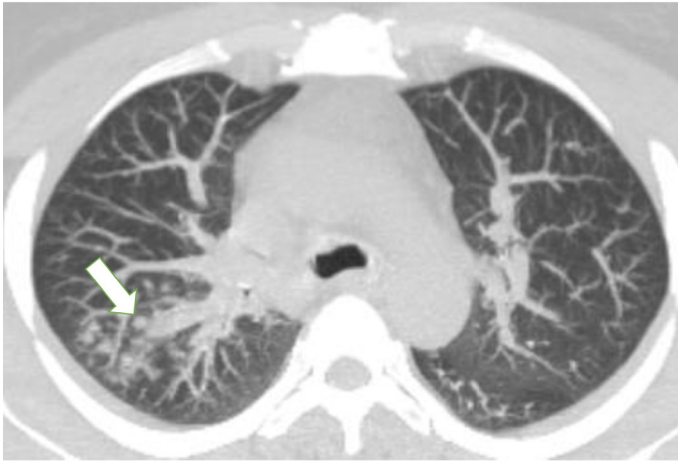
51-year-old woman who presented with fever and cough for 2 days. CT was performed on day of admission. Axial CT image shows centrilobular nodules in upper lobe of the right lung (arrow). Atypical CT finding for Covid-19 pneumonia
